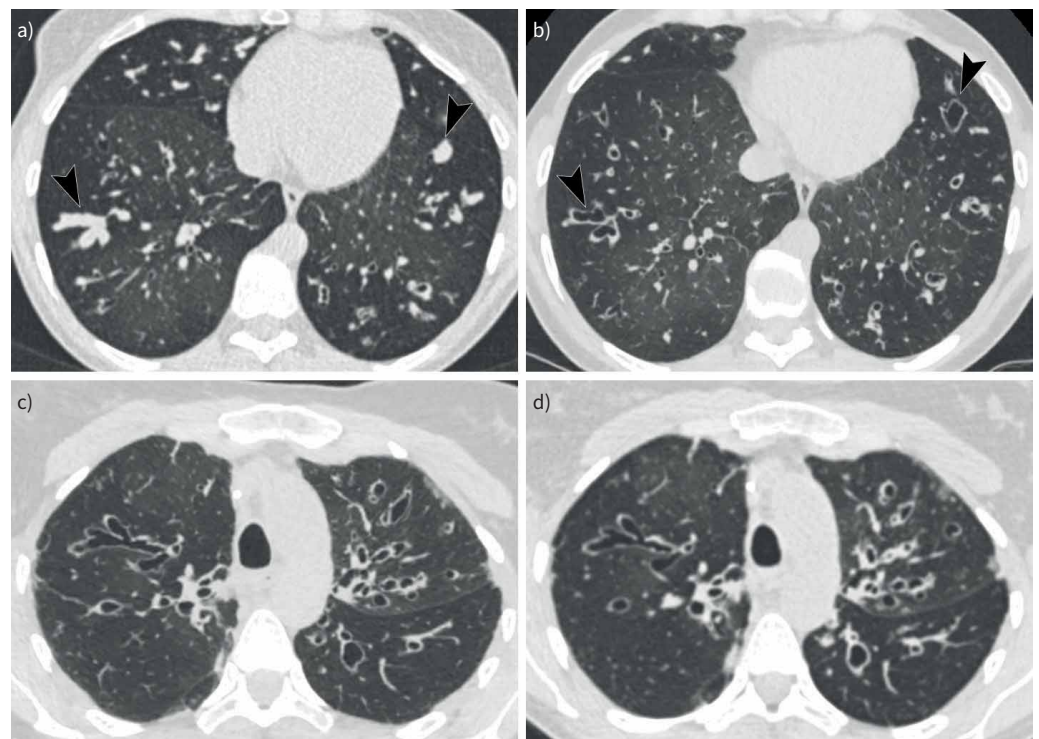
Side-by-side comparison of unenhanced chest computed tomography (CT) scans acquired 10 months before (a, c) and 1 year after (b, d) initiation of lumacaftor–ivacaftor in a 30-year-old female patient. Comparison shows the disappearance of mucus plugging (arrowheads) from image a to b, but a stability of the bronchiectasis from c to d. The Bhalla score was 16 before initiation of lumacaftor–ivacaftor and 13 after 1 year of lumacaftor–ivacaftor.
